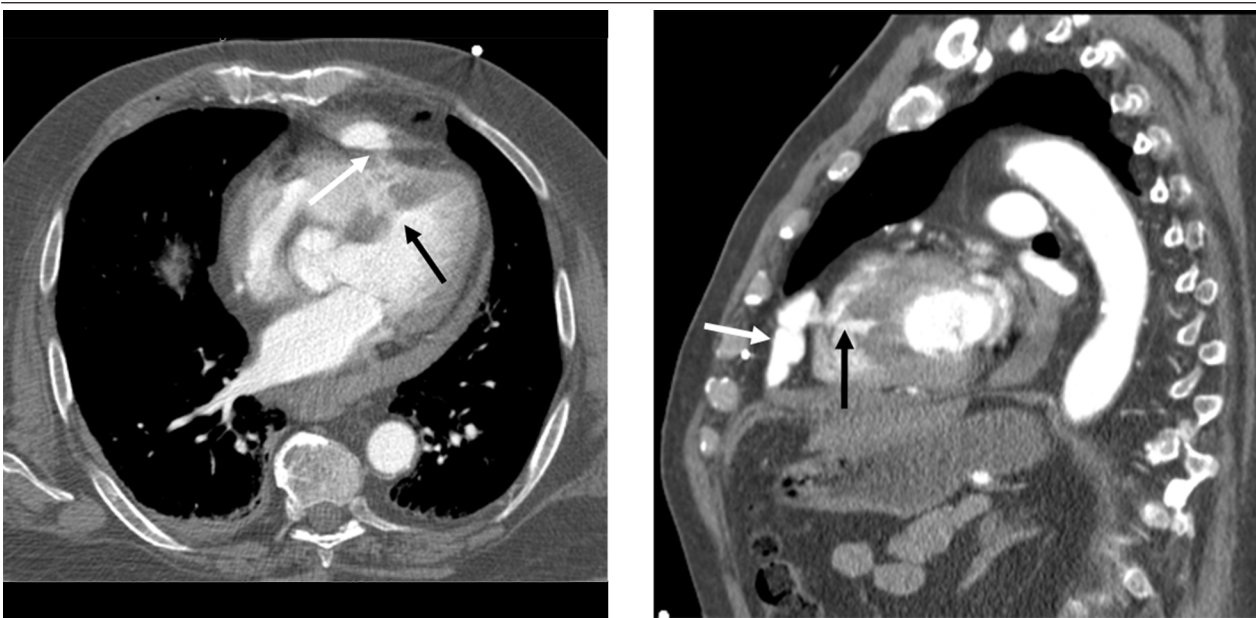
Contrast enhanced CT chest in a patient who had a motor vehicle accident one week earlier. Original CT depicted sternal and rib fractures with no hemopericardium. Follow up contrast enhanced chest CT at the level of the aortic root (A) and interventricular septum (B) demonstrates a large delayed hemopericardium (white arrows). Sternal and rib fractures are also seen (black arrows).
